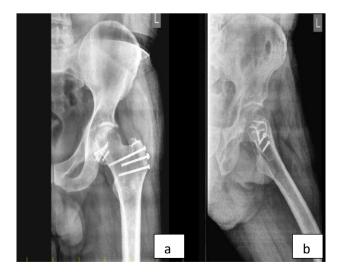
(a and b): X-rays showing well maintained femur head contour.
